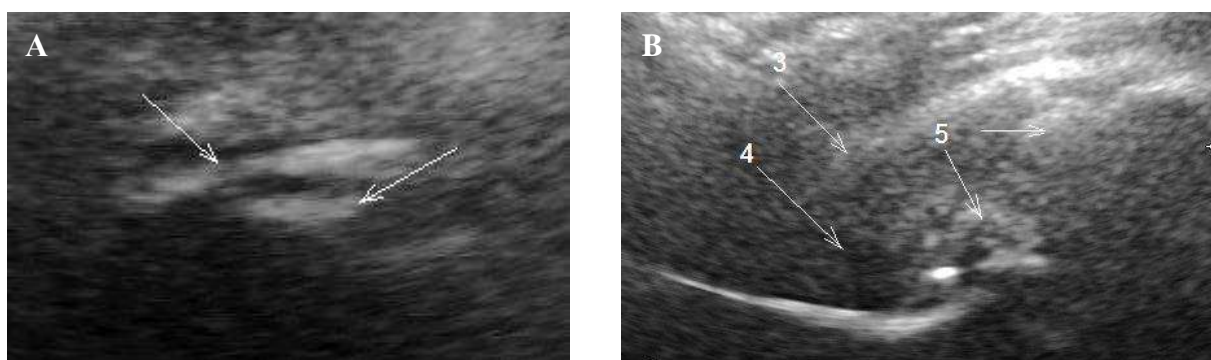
A sonogram of a patient S., 22 years old.
